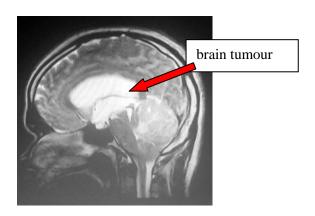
13: Magnetic Resonance Image of the head showing a large brain tumour and obstructive hydrocephalus.
